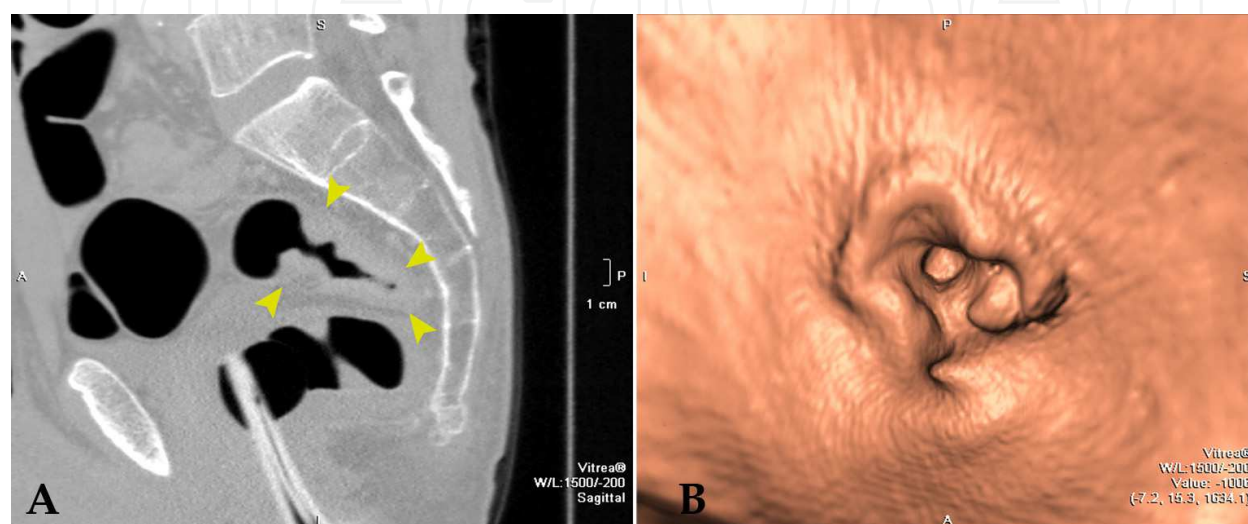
Incomplete colonoscopy because of a stenotic cancer of the rectum. (A) 2D sagittal CT colonographic image shows circular wall thickening in the rectum (arrowheads). (B) 3D CT colonographic image shows an irregular, circular, stenotic filling defect.
